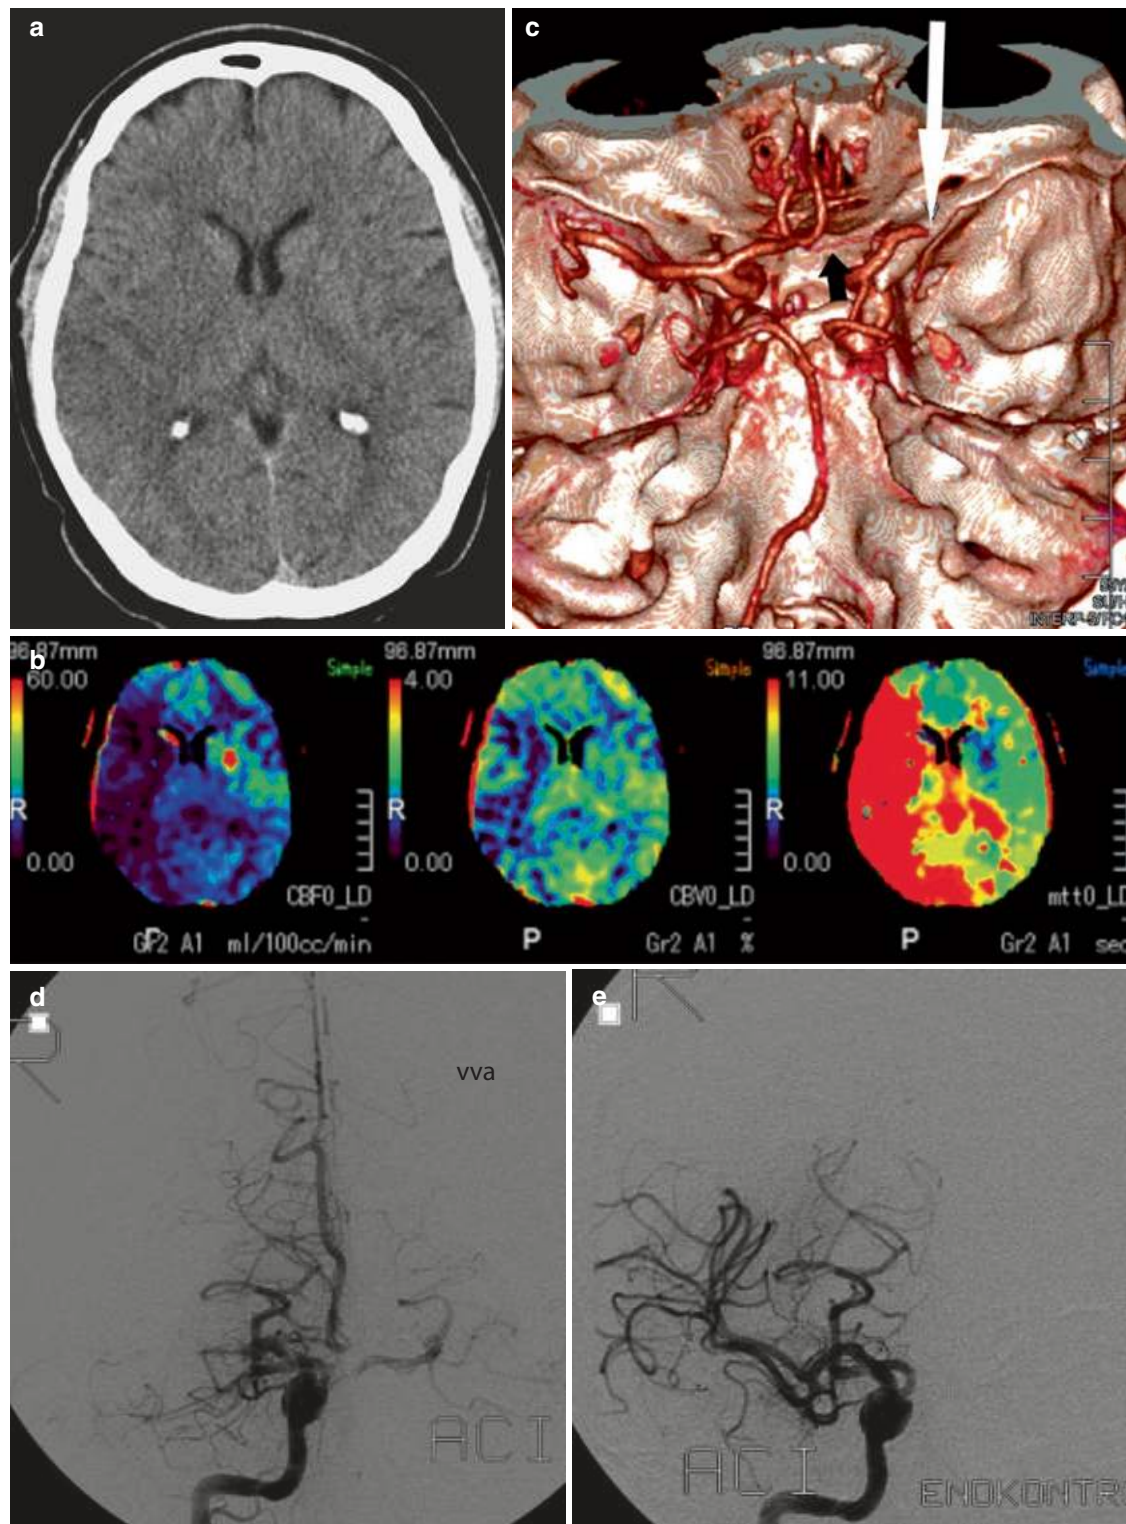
Thrombosis of the MCA. A 60-year-old man with acute hemiplegia of the left side (time window: 1.5 h). (a) Native CT with slight hypodensity of the right territory of the middle cerebral artery (MCA). Note the effacement of the grey and white matter distinction of the insular, basal ganglia, and fronto-temporal region with slight narrowing of the cortical sulci, compared with the left hemisphere, as early signs of infarction. (b) CT perfusion map, demonstrating the different areas of perfusion parameters with a related mismatch: elongated mean transit time (MTT) (right), reduced cerebral blood flow (CBF) (left), but relatively small reduction of cerebral blood volume (CBV) (middle). (c)
